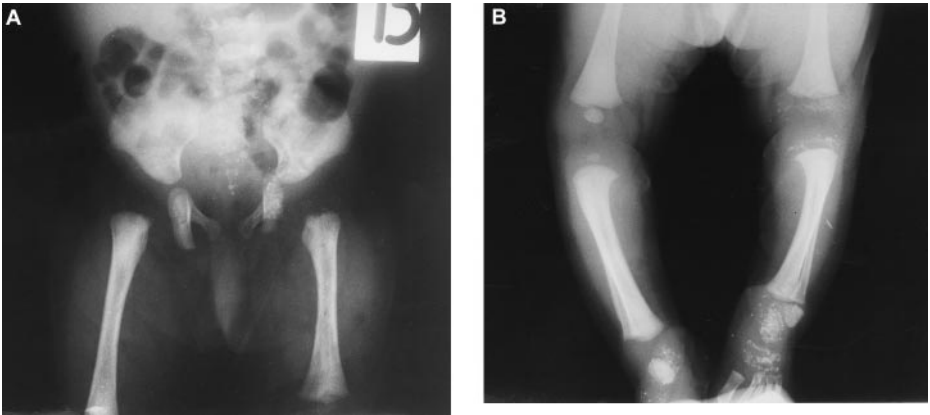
Conradi–Hünermann disease: X-rays of the pelvis (A) and lower limbs (B) of an infant. Note the puncture-like calcifications in the regions of the sacrum, pelvis (A) and in the areas of the knee and ankles (B).
